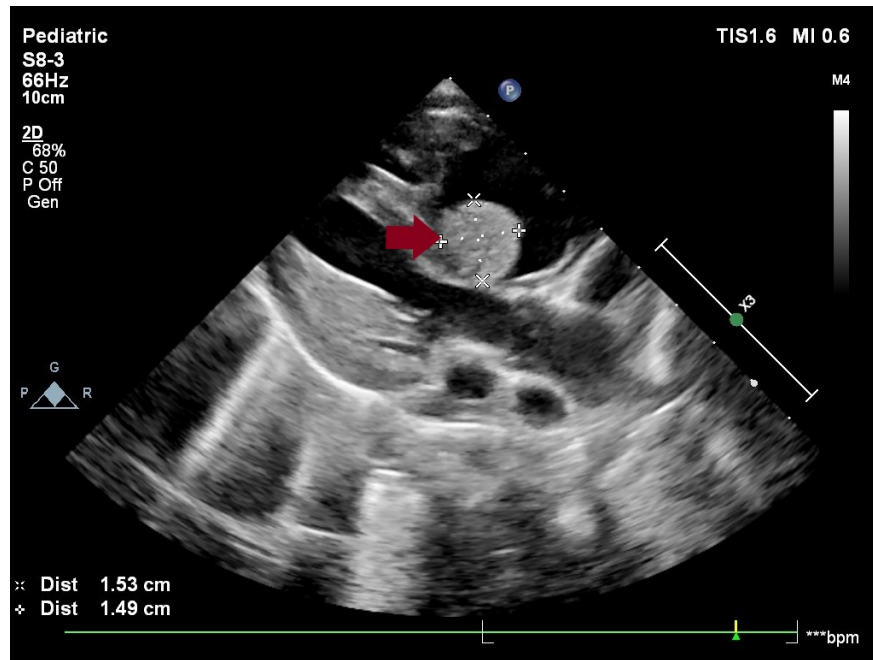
Modified parasternal long axis images of rhabdomyoma in TTE (indicated by the red arrow)
